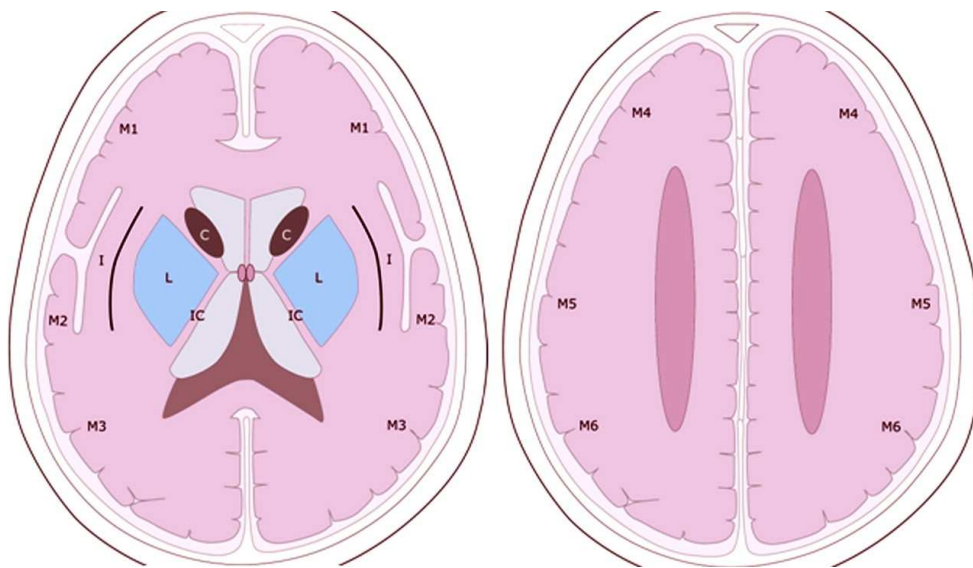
The Alberta Stroke Program Early Computerized Tomography Score (ASPECTS) and modified ASPECTS templates.
